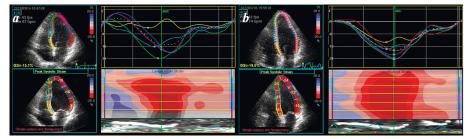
Results of echocardiographic study of patient: a - baseline, b - after radiofrequency ablation. Explanations in the text.
